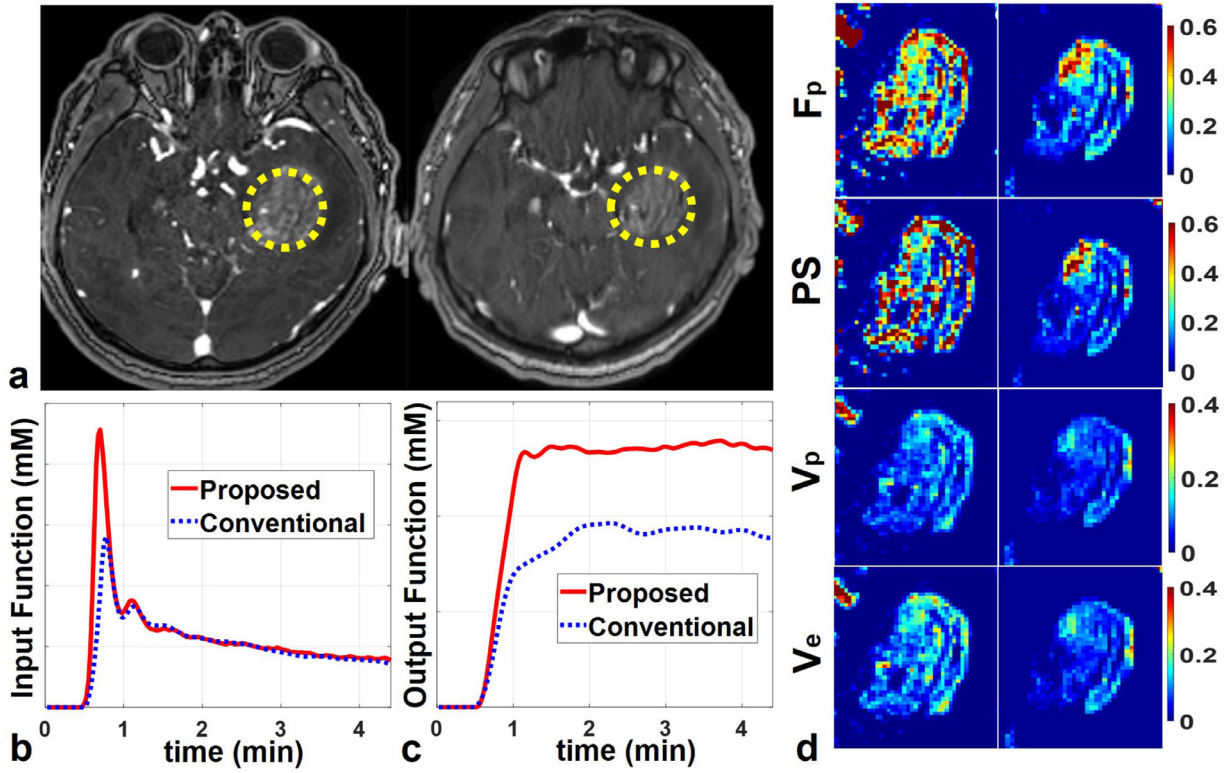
Comparison of DCE images (a), input (b) and output (c) functions, perfusion and permeability maps (d) between the proposed high-definition DCE MRI and conventional routine DCE MRI. Note that compared with conventional DCE MRI the proposed method yields sharper DCE images (a), highly defined input and output functions (b, c), and improved microvascular function parameters (d).
